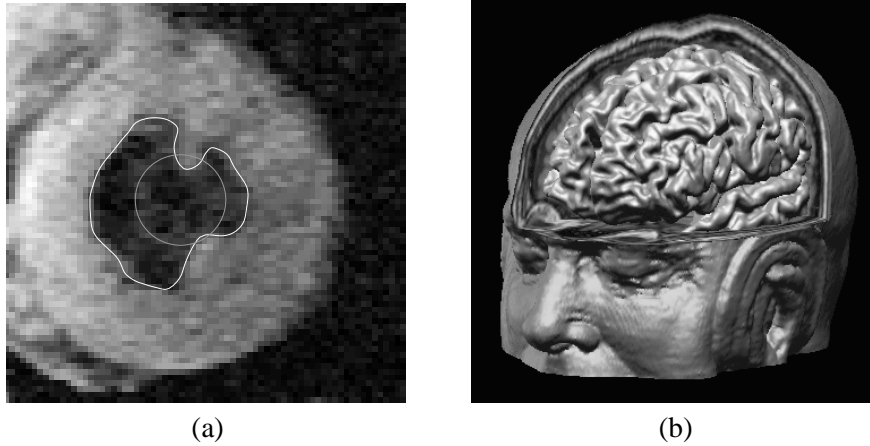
(a) A 2-D example of using a deformable contour to extract the inner wall of the left ventricle of a human heart from an MR image. The initial deformable contour (plotted in gray) and the final converged result (plotted in white). (b) A 3-D example of using a deformable surface to reconstruct the brain cortical surface from a 3-D MR image.
